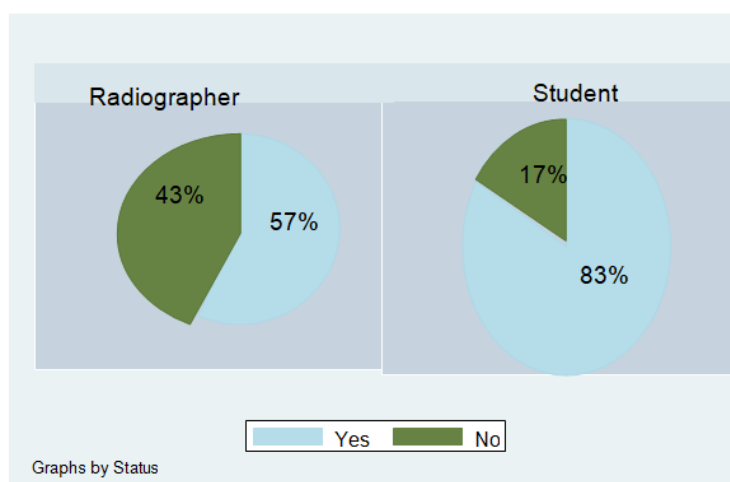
Comparison between radiographers and students
